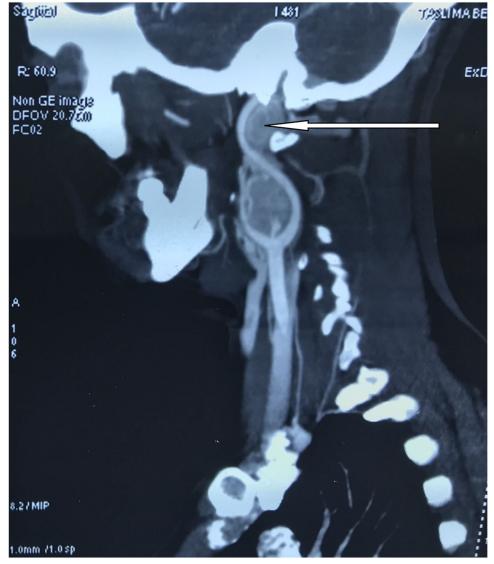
Contrast enhancing computed tomography of neck (saggital section) showing a bi-lobed carotid body paganglioma with encasement of carotids (Shamblin III) with superior extension to the base of skull (arrow).
